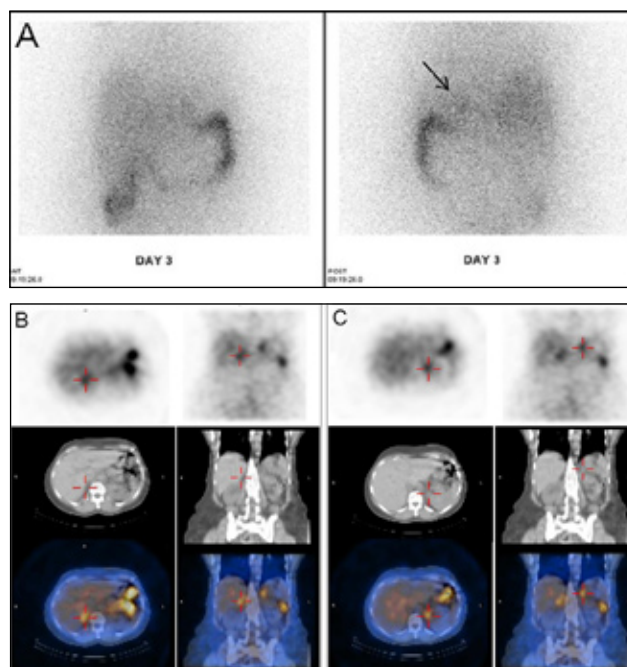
A case of IHA imaged with NP-59. A: Planar images demonstrate early visualization of the left adrenal (arrow) thereby falsely suggesting APA. Identification of the right adrenal is obscured by superimposition of liver activity which is high on day 3. B: and C: SPET/CT performed on the same day permits early detection of both adrenal cortices, which leads to the correct diagnosis of IHA (BAH). (Images from the department of Nuclear Medicine University Hospital Rion-Greece)
